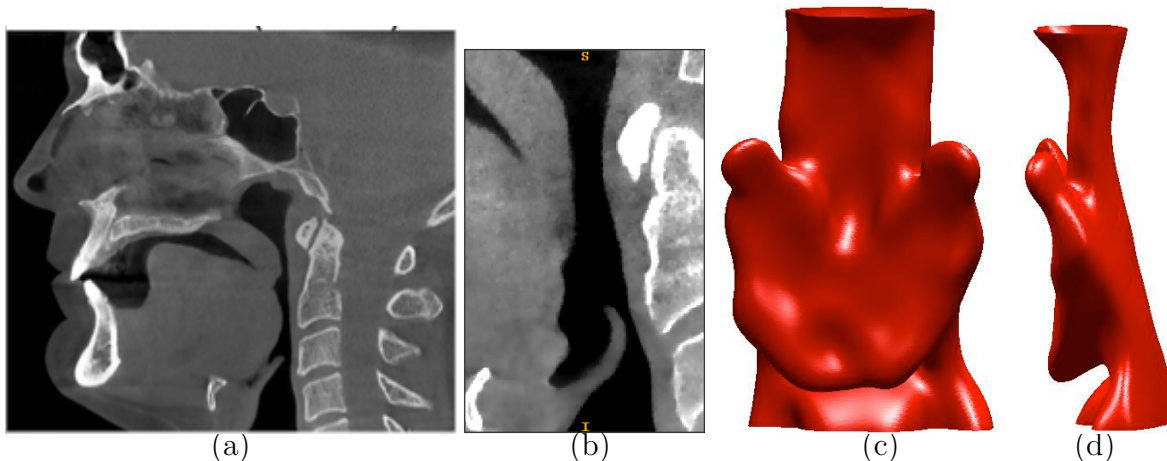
Original cone-beam CT scan: single slice (a) and region of interest (b). Anterior (c) and anteroposterior (d) views of reconstructed level set.
